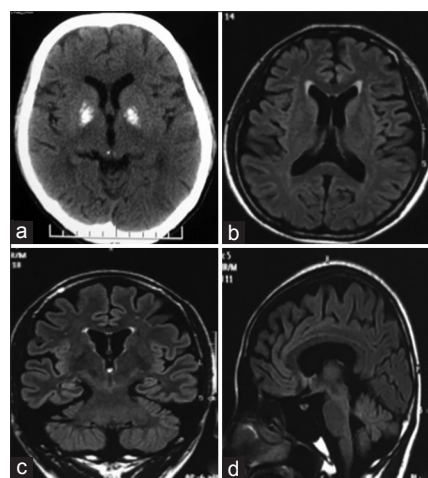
CT and MRI of MERRF patients. CT showed the calcification of basal ganglia (a). Axial (b), coronal (c), sagittal (d) MRI showed atrophy of cerebrum and cerebellum. CT: Computed tomography; MRI: Magnetic resonance imaging; MERRF: Myoclonic epilepsy with ragged-red fiber.
